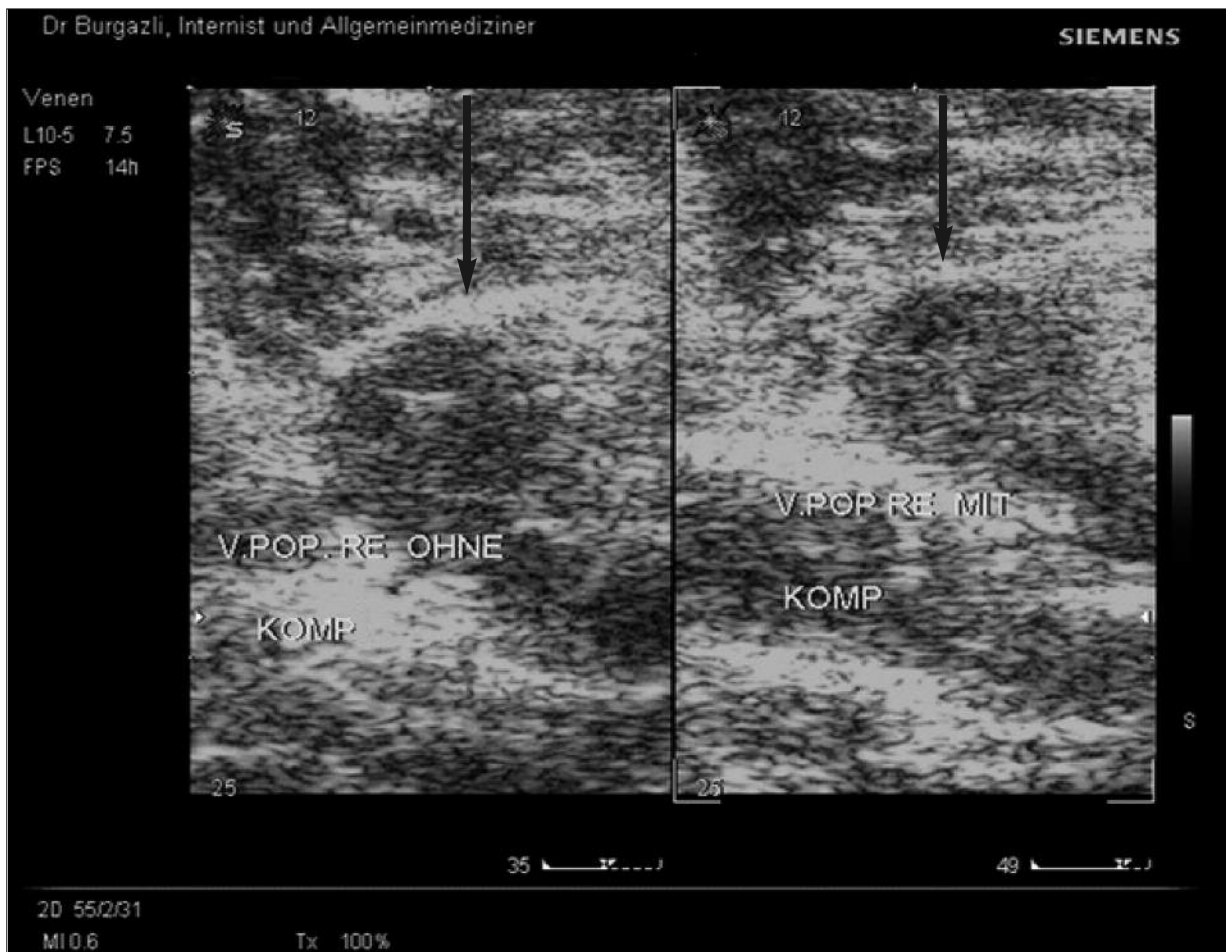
Compression ultrasonography (CUS). Left arrow shows vein before the compression. Right arrow shows compressed view of the vein.
